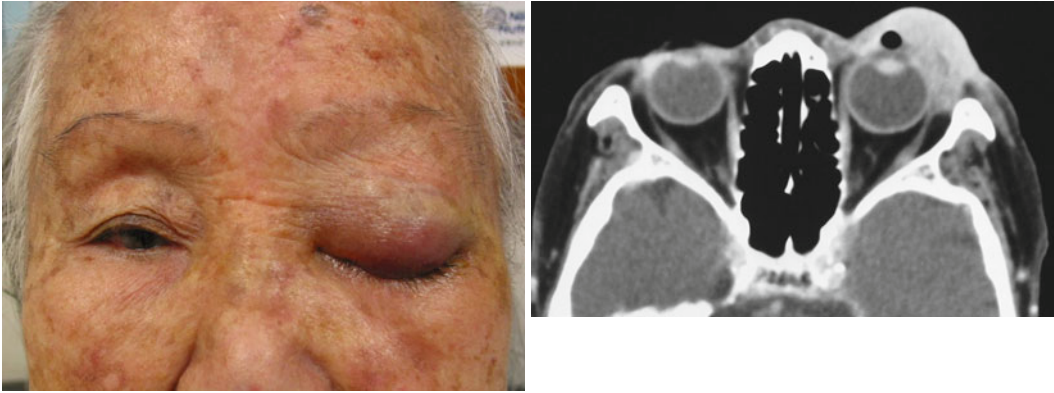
(a, b) Diffuse left upper lid swelling with erythema and secondary blepharoptosis. CT scan showed diffuse infiltrative left upper lid lesion. Subsequent biopsy confirmed eyelid T cell lymphoma
